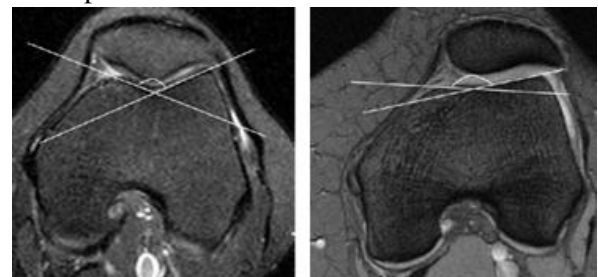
trochlear dysplasia. (a) Normal trochlear groove in a SPIR T2-weighted section in the axial plane (groove angle, <150°), and (b) hypoplastic trochlear groove in a fat-suppressed SE T2-weighted section in the axial plane (groove angle, >150°) are observed drawn tangent to the posterior femoral condyle is measured. It was reported that this angle was $\geq 10^\circ$ in patients with a distinct patellar tilt in physical examination.
